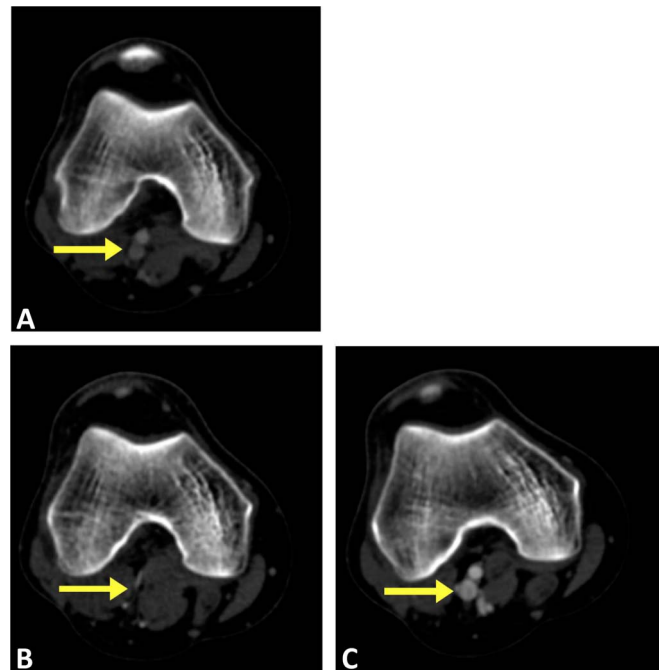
Axial CTA images of the popliteal artery and vein. A, Pre-treatment at rest demonstrates patency of the popliteal artery and vein, no variant anatomy, (B) pretreatment with active plantar flexion against resistance demonstrates complete compression of the popliteal vein and near complete compression of the popliteal artery, (C) 6 months after botulinum toxin treatment with active plantar flexion against resistance demonstrates no residual compression of the vascular structures. CTA, CT angiography.
